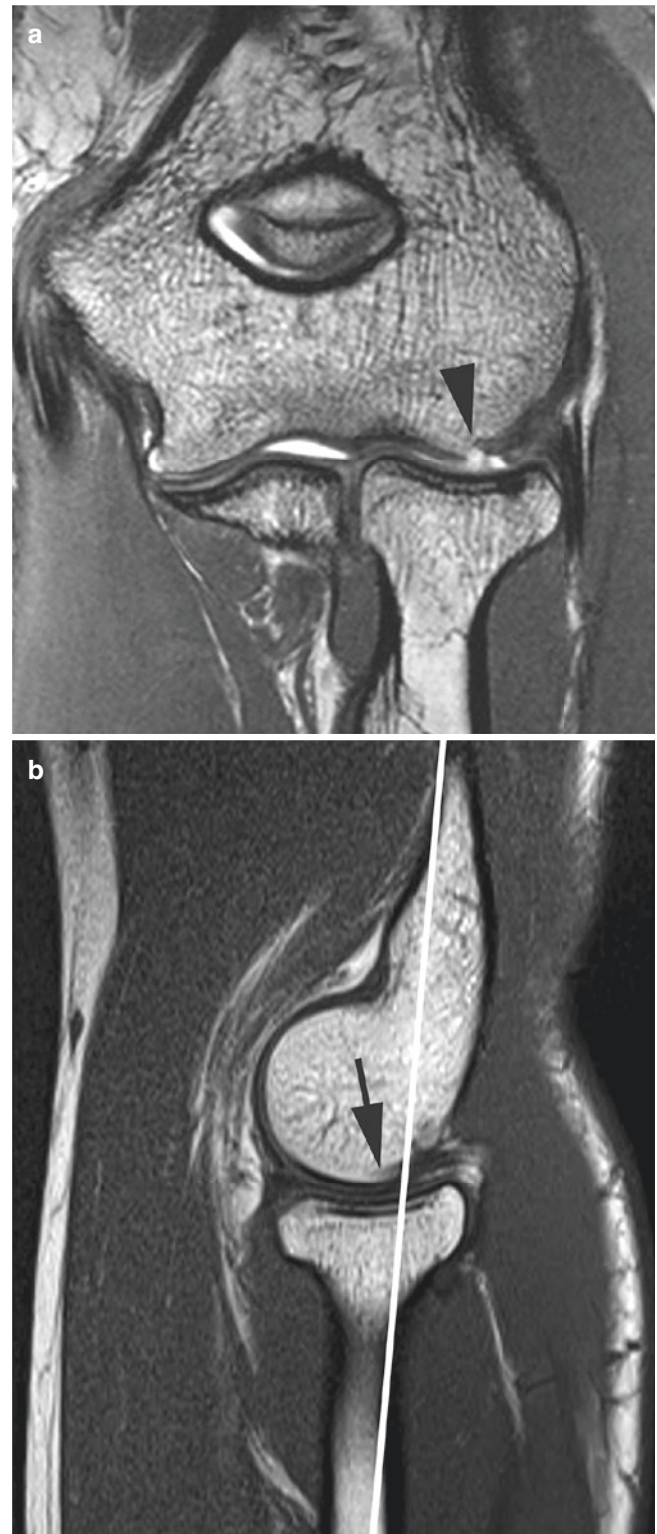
Pseudodeflect of the capitellum. (a) Coronal gradient echo T2*-weighted image shows an apparent osteochondral lesion along the surface of the capitellum (arrowhead). (b) Correlative sagittal T1-weighted image reveals that the coronal slice (white line) lies just posterior margin of the articular surface (arrow)
